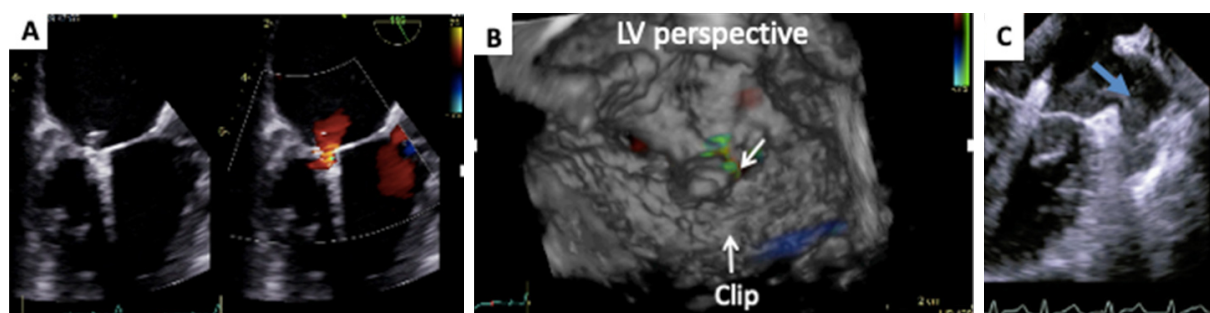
Assessment of Leaflets Insertion: Indirect Signs. 2D color Doppler (A) and 3D LV perspective (B) showing a residual intraclip jet; appearance of spontaneous echocontrast after leaflet grasping (C). LV: left ventricle
